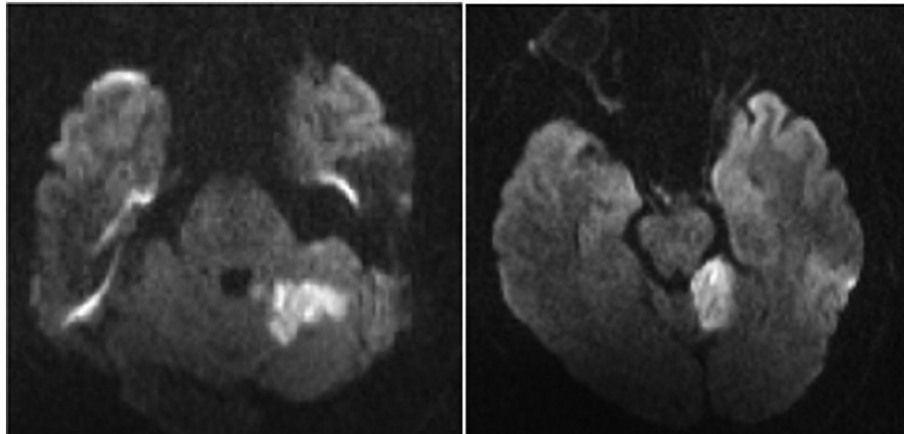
MRI DWI showing an acute ischemic lesion in the territory of the left superior cerebellar artery.
